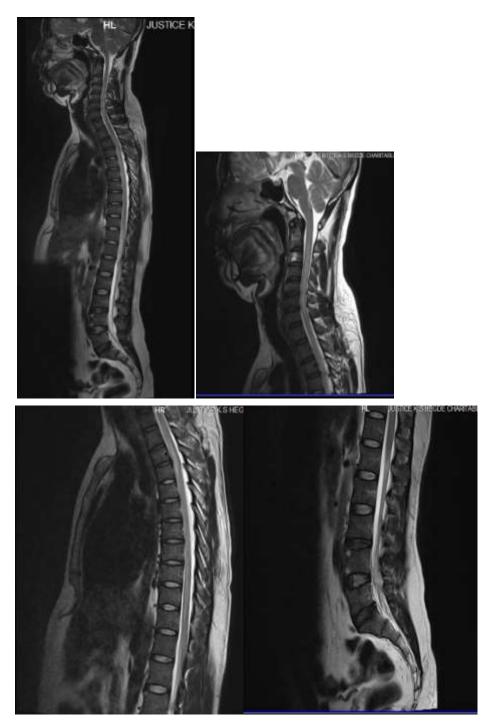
MRI spine showing long segment intramedullary hyperintensity extending from C2 to T10 level suggestive of Transeverse Myelitis
